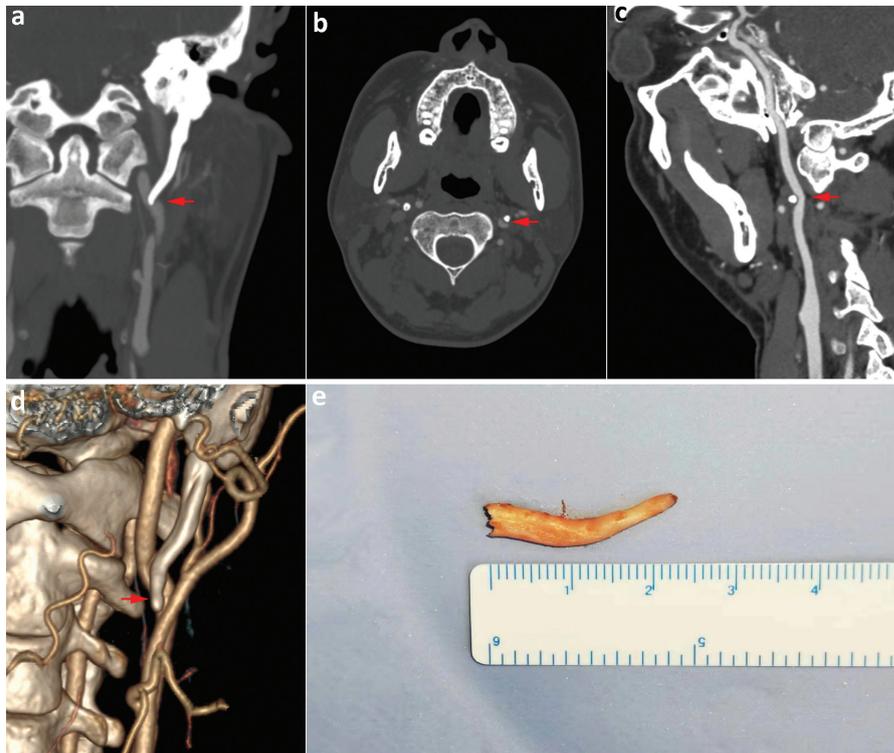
a–d) Computed tomography angiography showing an elongated on left styloid process causing compression of left internal carotid artery extracranially. e) The excised left styloid process.
